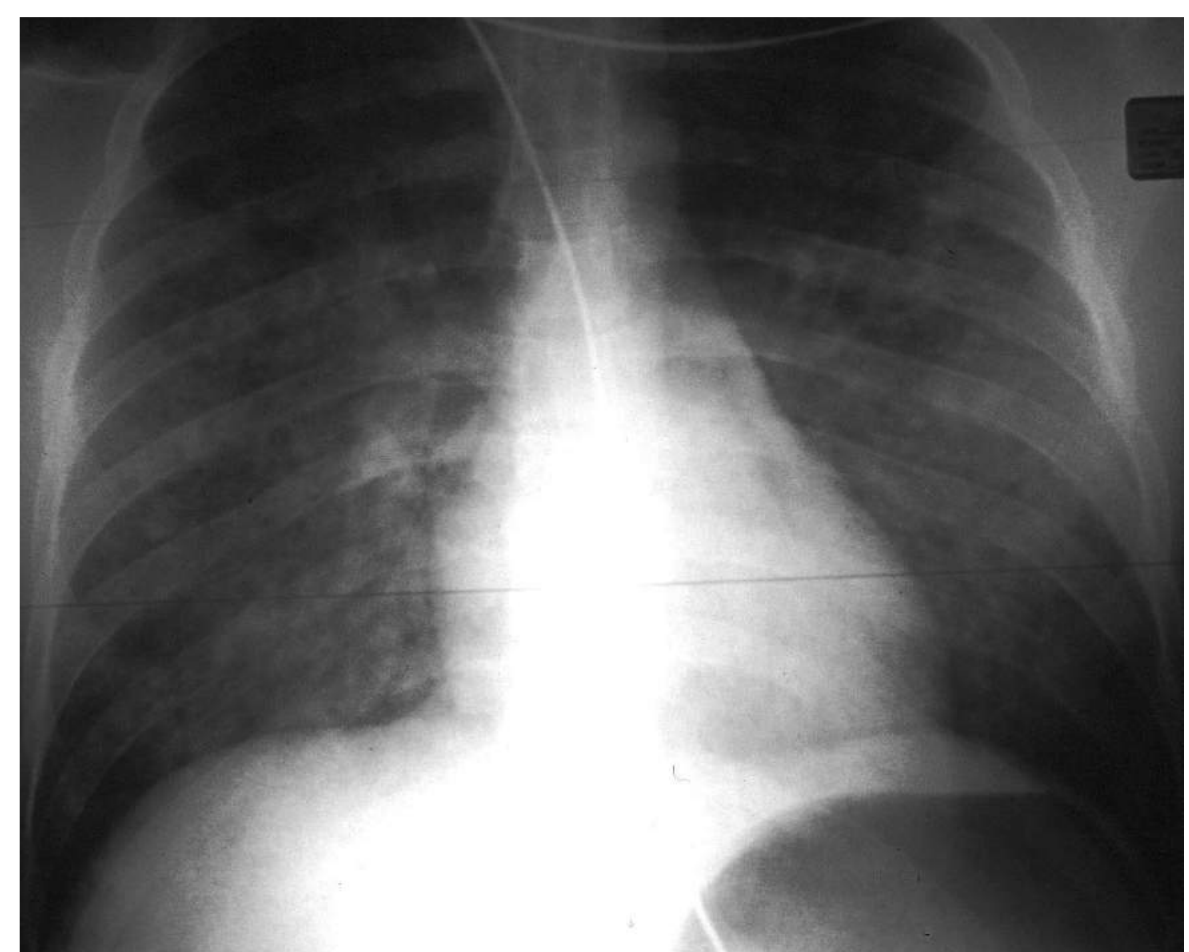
■ Heroin-Related Noncardiogenic Pulmonary Edema. Noncardiogenic pulmonary edema may occur in the setting of opioid poisoning. The radiograph demonstrates the bilateral airspace opacities and the normal-sized cardiac silhouette. (Photo contributor: Division of Medical Toxicology, University of California, San Diego.)
